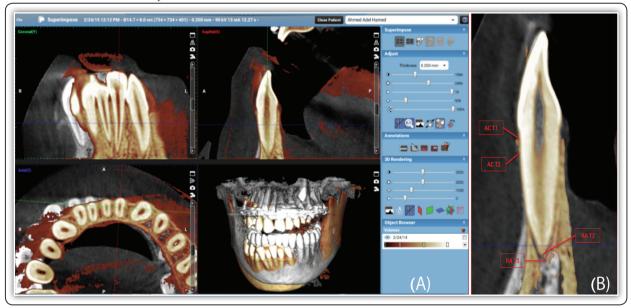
(A) Completed 3D superimposition of bothT1 and T2 CBCT scans by the best-fit method between two sets of homologous landmarks. (B) CBCT image of a lower incisor tooth after manual refinement process based on its long axis and anatomical crown with linear measurements in sagittal view of superimposed T1 and T2 images.
